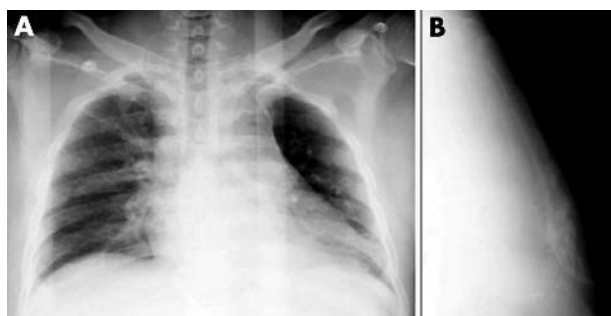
(A) Anteroposterior chest radiograph in the supine position shows widened upper mediastinum and increased cardiothoracic ratio. (B) Lateral sternum radiograph demonstrates no subtle fracture line or displacement.
